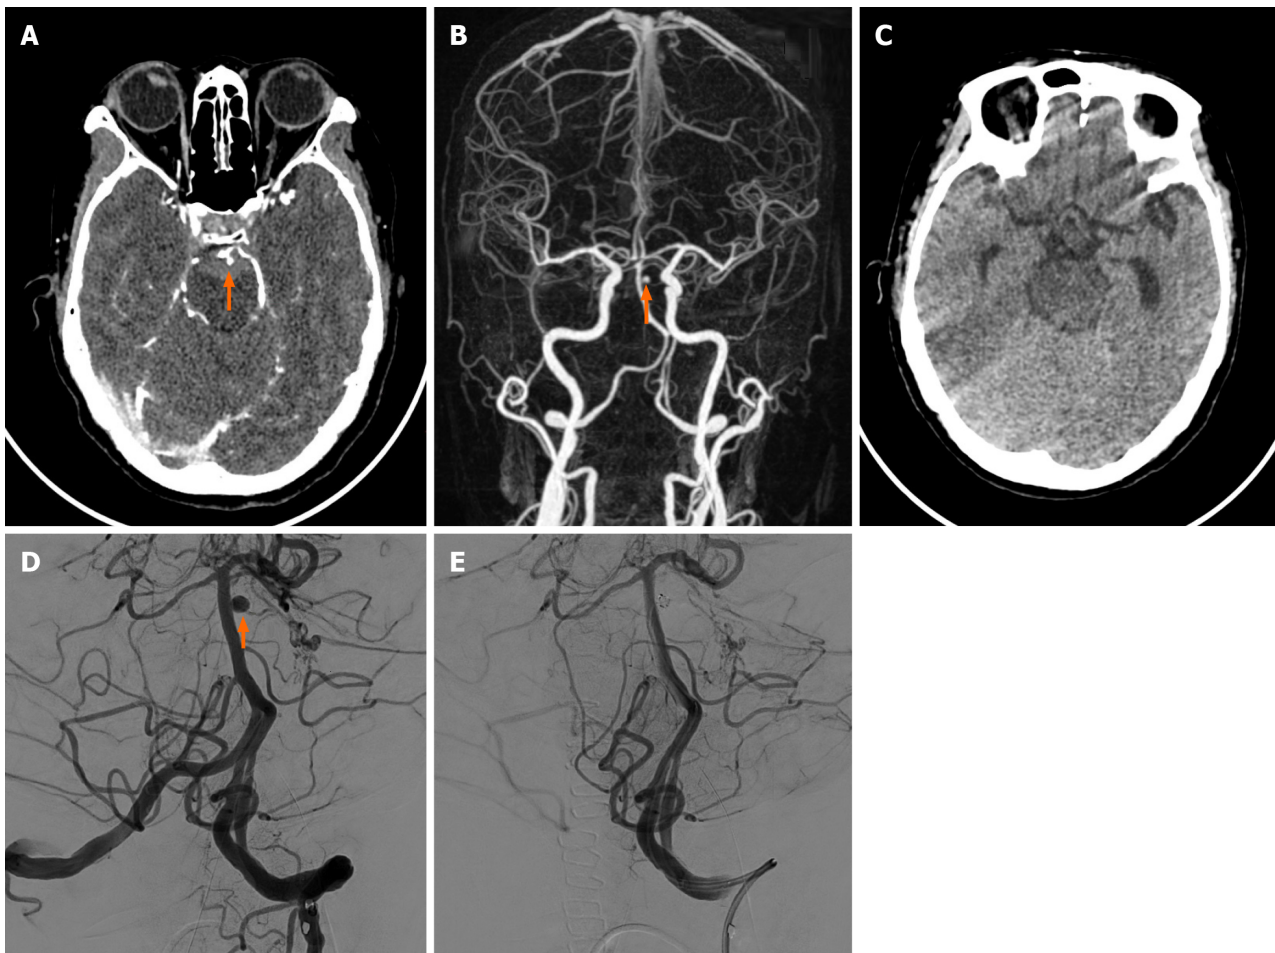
Case 1. A: Axial enhanced brain computed tomography of a 58-year-old female showed a tiny aneurysm found in the left superior cerebellar artery. Subarachnoid hemorrhage was noted; B: Three-dimensional reconstruction showed a 4.2 mm × 3.0 mm × 2.6 mm aneurysm found in the left superior cerebellar artery; C: Follow-up brain computed tomography (24 months post-operation) showed no new subarachnoid hemorrhage; D: Angiography showed the aneurysm noted on the left side of the basilar artery was clearly visualized by the frontal and lateral views; E: A 3.0 mm × 80.0 mm metallic coil was impacted into the aneurysm sac. Follow-up angiogram confirmed complete embolization and parent artery was intact.
